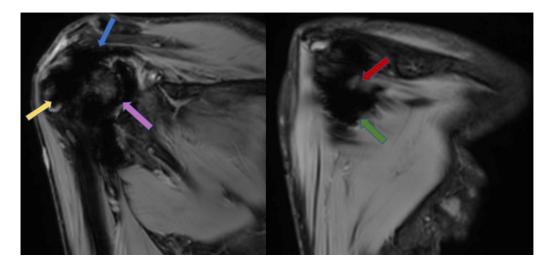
MRI right shoulder joint, Coronal sections SWI sequence shows: the tendon of supraspinatus (blue arrow), subscapularis (pink arrow), long head of biceps (yellow arrow), infraspinatus (red arrow) and teres minor (green arrow) at the insertion site showing blooming on SWI suggestive of hemosiderin deposition.
